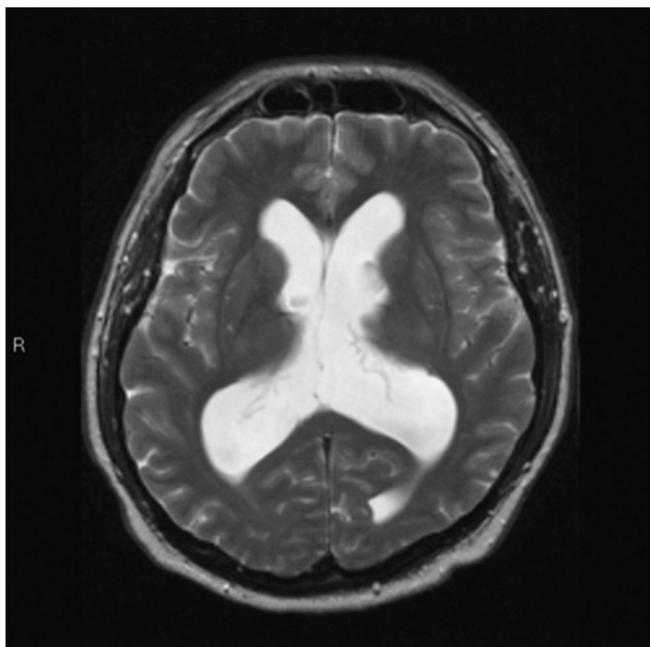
Primary hydrocephalus categorized as EMBL. T2W MRI scan demonstrates ventricular enlargement in a 53 year old with adult normal pressure hydrocephalus, gait and cognitive deficits, and Parinaud's syndrome.
